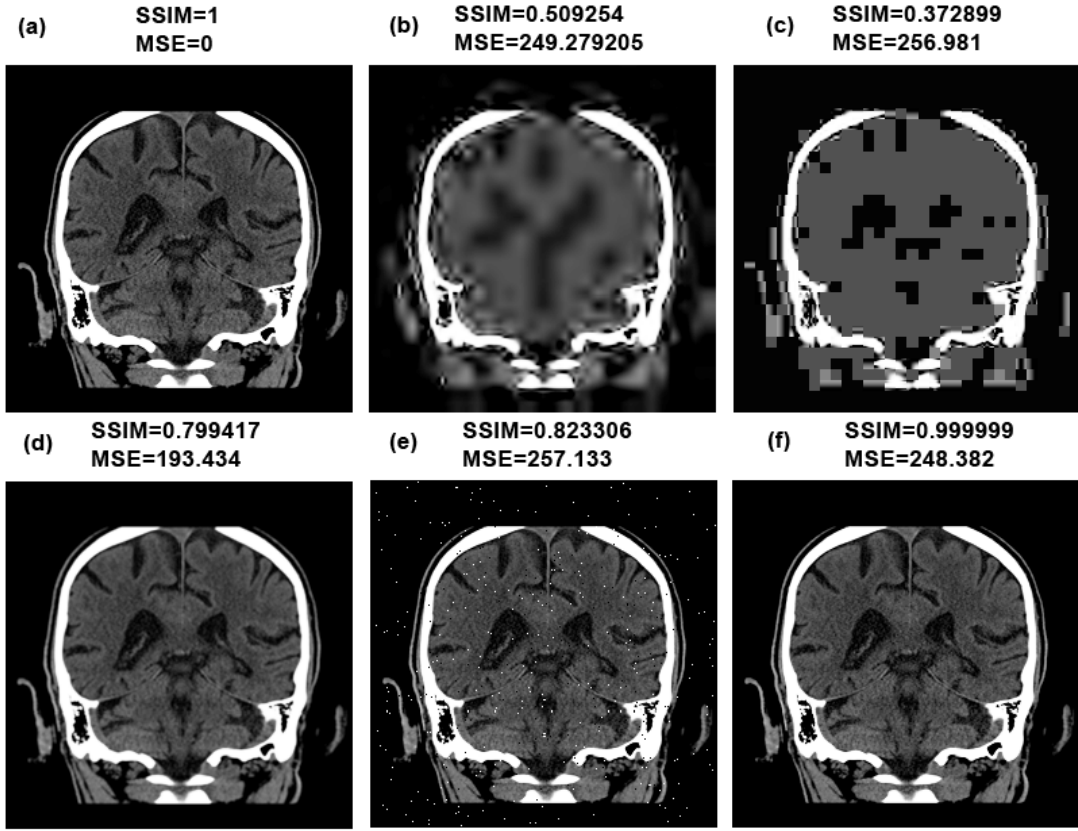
MSE and SSIM comparison. (Brain CT image: MIIRC@M) (a) the original brain CT image, (b) JPEG2000 highly compressed image, (c) JPEG highly compressed image, (d) luminance shifted image, (e) salt-and-pepper noise added (f) contrast enhanced image.
